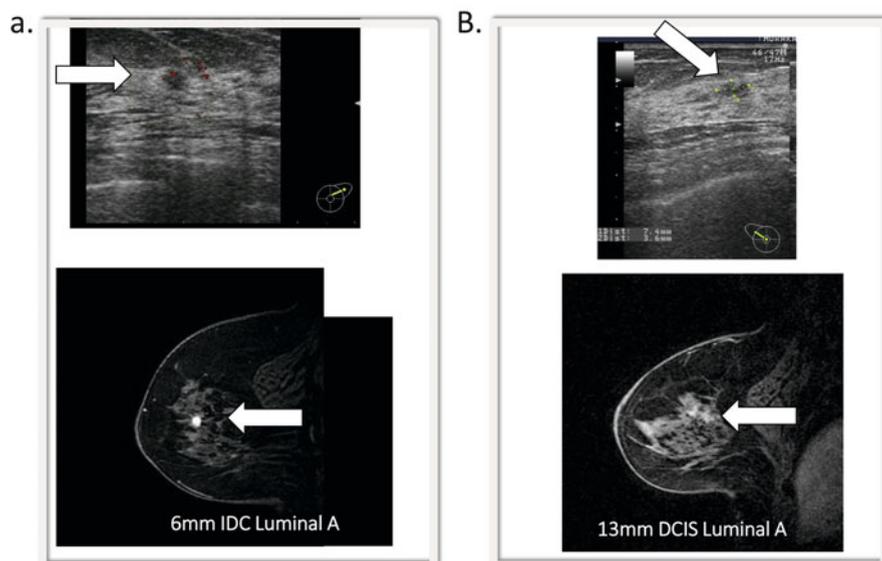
Candidates are selected with breast imaging. (a) Candidate. Both ultrasonography and breast MRI showed localised lesion less than 10 mm (white arrows). (b) Not candidate. Although the lesion was less than 10 mm with ultrasonography (white arrow), breast MRI disclosed 13 mm long lesion
